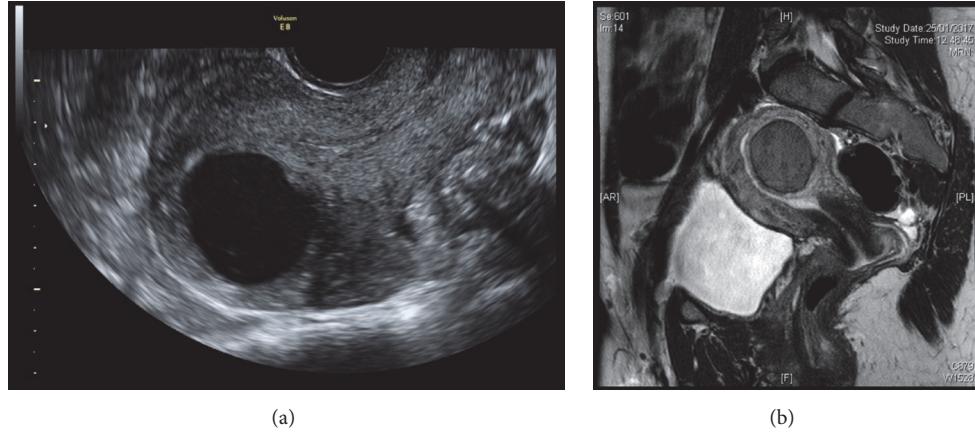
(a) Ultrasound and (b) MRI appearance of a cystic adenomyoma.
